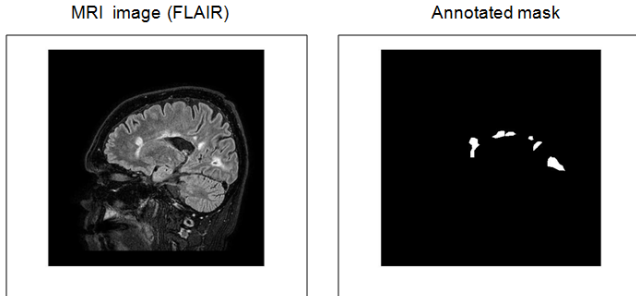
Raw FLAIR image (622x541) pixel by pixel annotated
